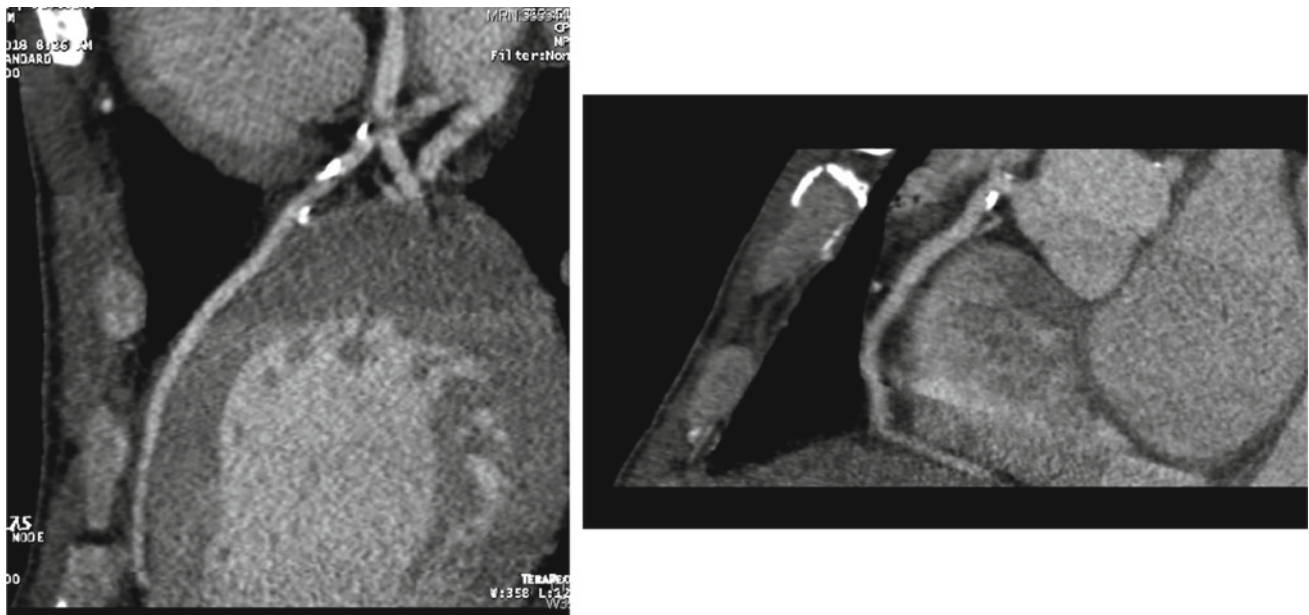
CTA showing non-obstructive CAD
